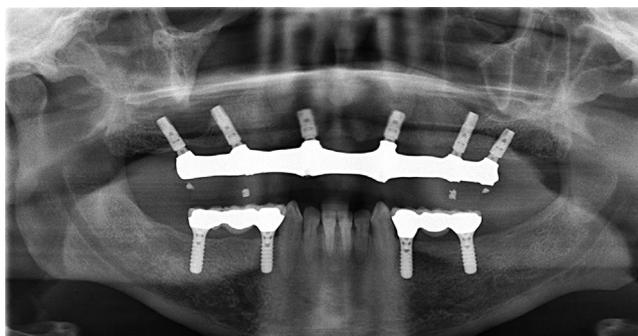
Panoramic radiograph showing stable bone levels around affected implant similar to remaining implants. Implants placed 10 years earlier.
